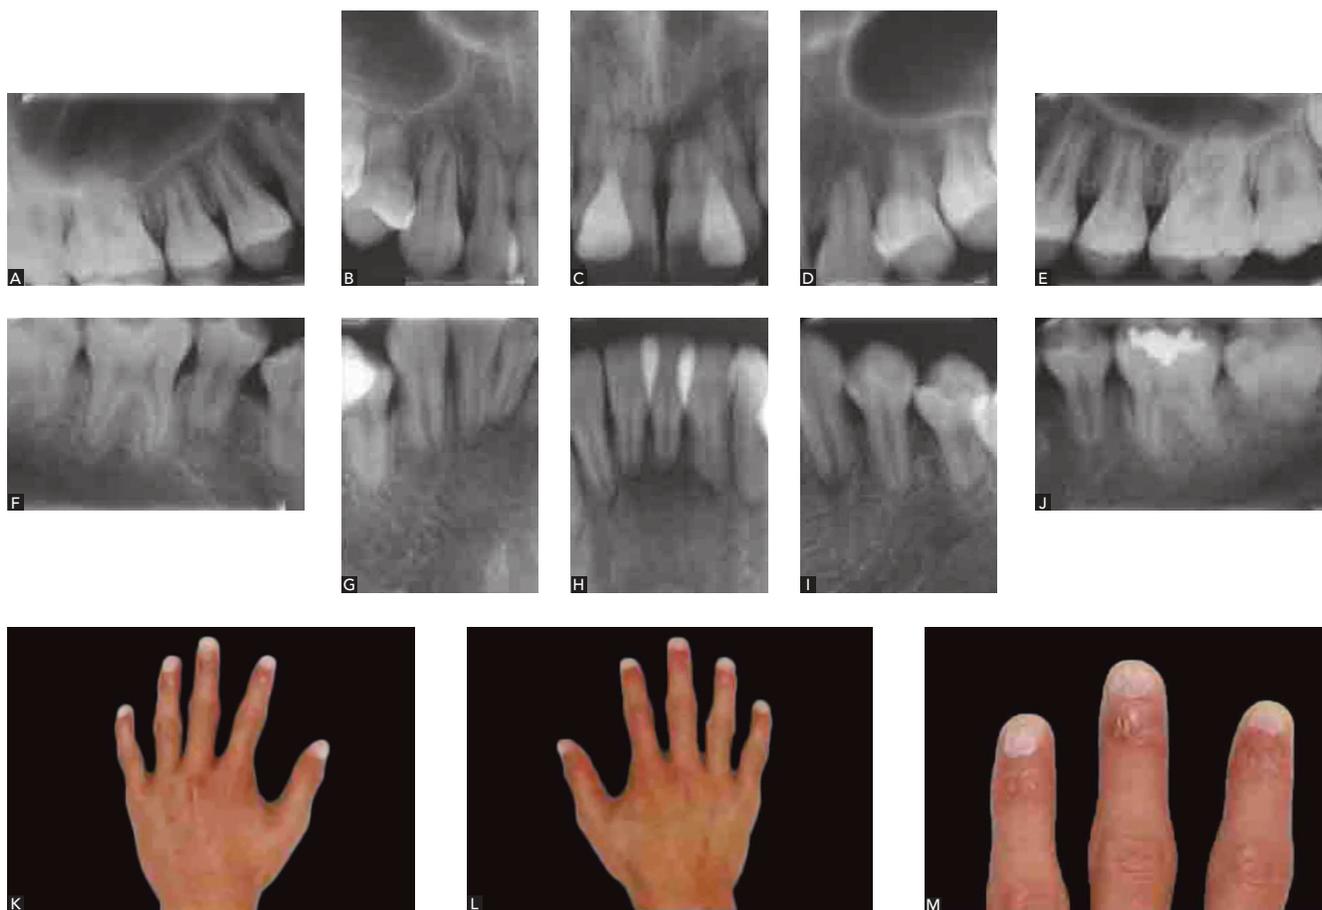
Generalized short root anomaly in patient with congenital dyskeratosis syndrome (a predominantly recessive X-linked syndrome, characterized by the triad of skin hyperpigmentation, membrane leukoplakia and nail dystrophy). A-J) Periapical radiographs; K-M) Photographs of right and left hands showing nail involvement.
